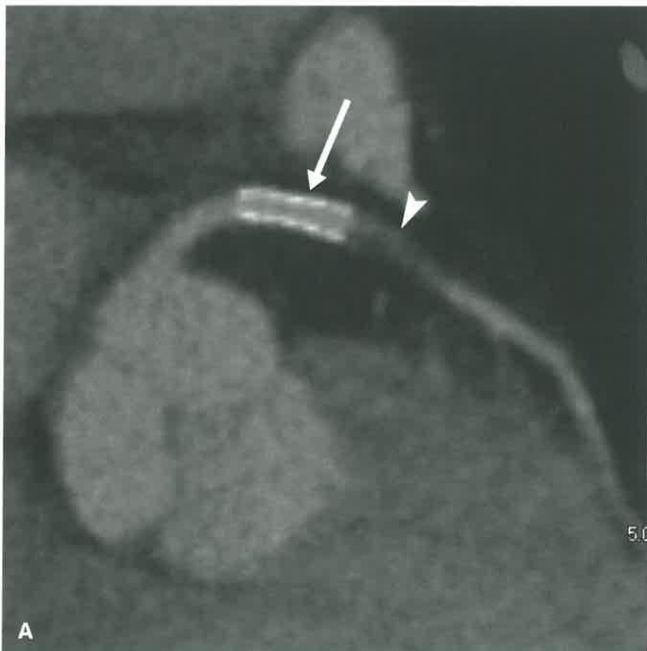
Stent Evaluation Using Coronary CTA. A: Curved MPR image through the LAD in a 59-year-old woman with chest pain shows a patent stent (*white arrow*) with no in-stent restenosis. However, there is a severe stenosis distal to the stent (*white arrowhead*). B: Curved MPR through the LAD in a 66-year-old man demonstrates an area of hypoattenuation in the distal aspect of the stent due to in-stent restenosis (*white arrow*). In addition, there are moderate stenoses in the LAD proximal and distal to the stent (*white arrowheads*). While the negative predictive value for CTA in assessing in-stent restenosis is high, the positive predictive value is low.
